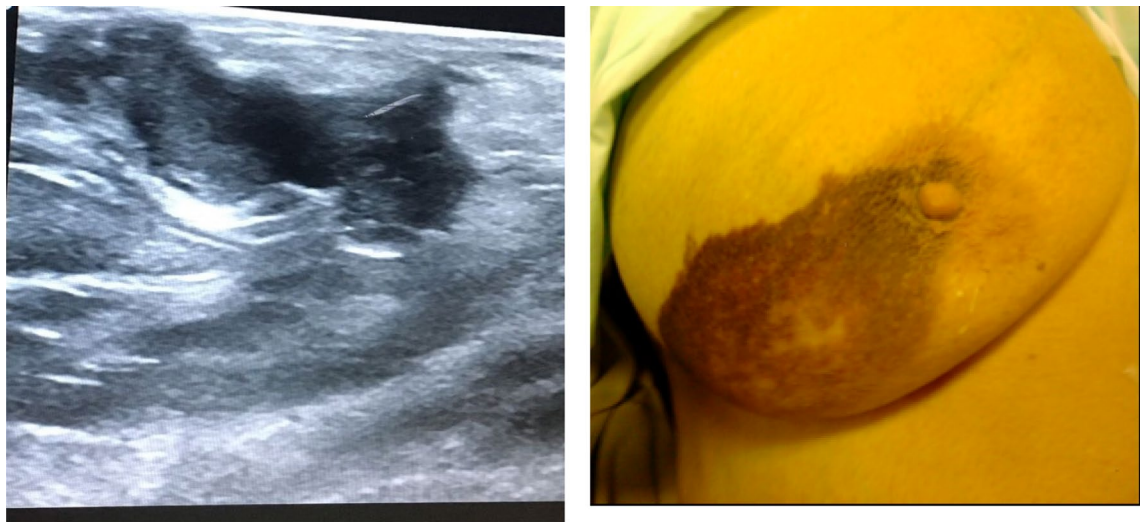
a, b Breast hematoma evident in ultrasound and clinical examination
